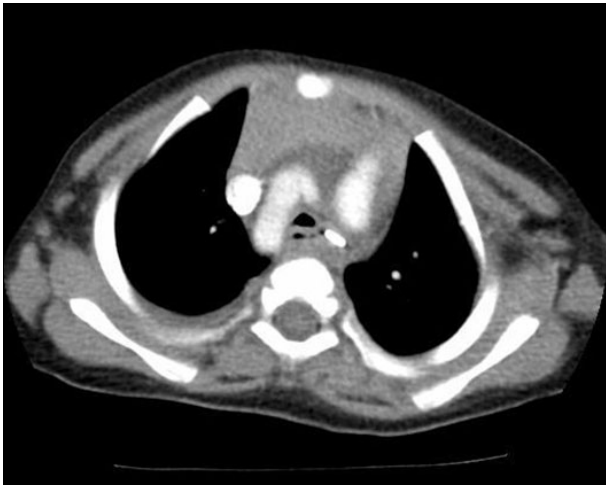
Postoperative computed tomography scan shows markedly alleviated Kommerell's diverticulum and surgical clip.
